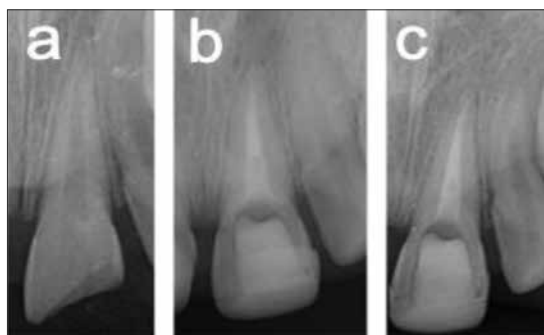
Radiographic appearance of case 4; a – preoperative; b – postoperative; c – postoperative 24-month follow-up
